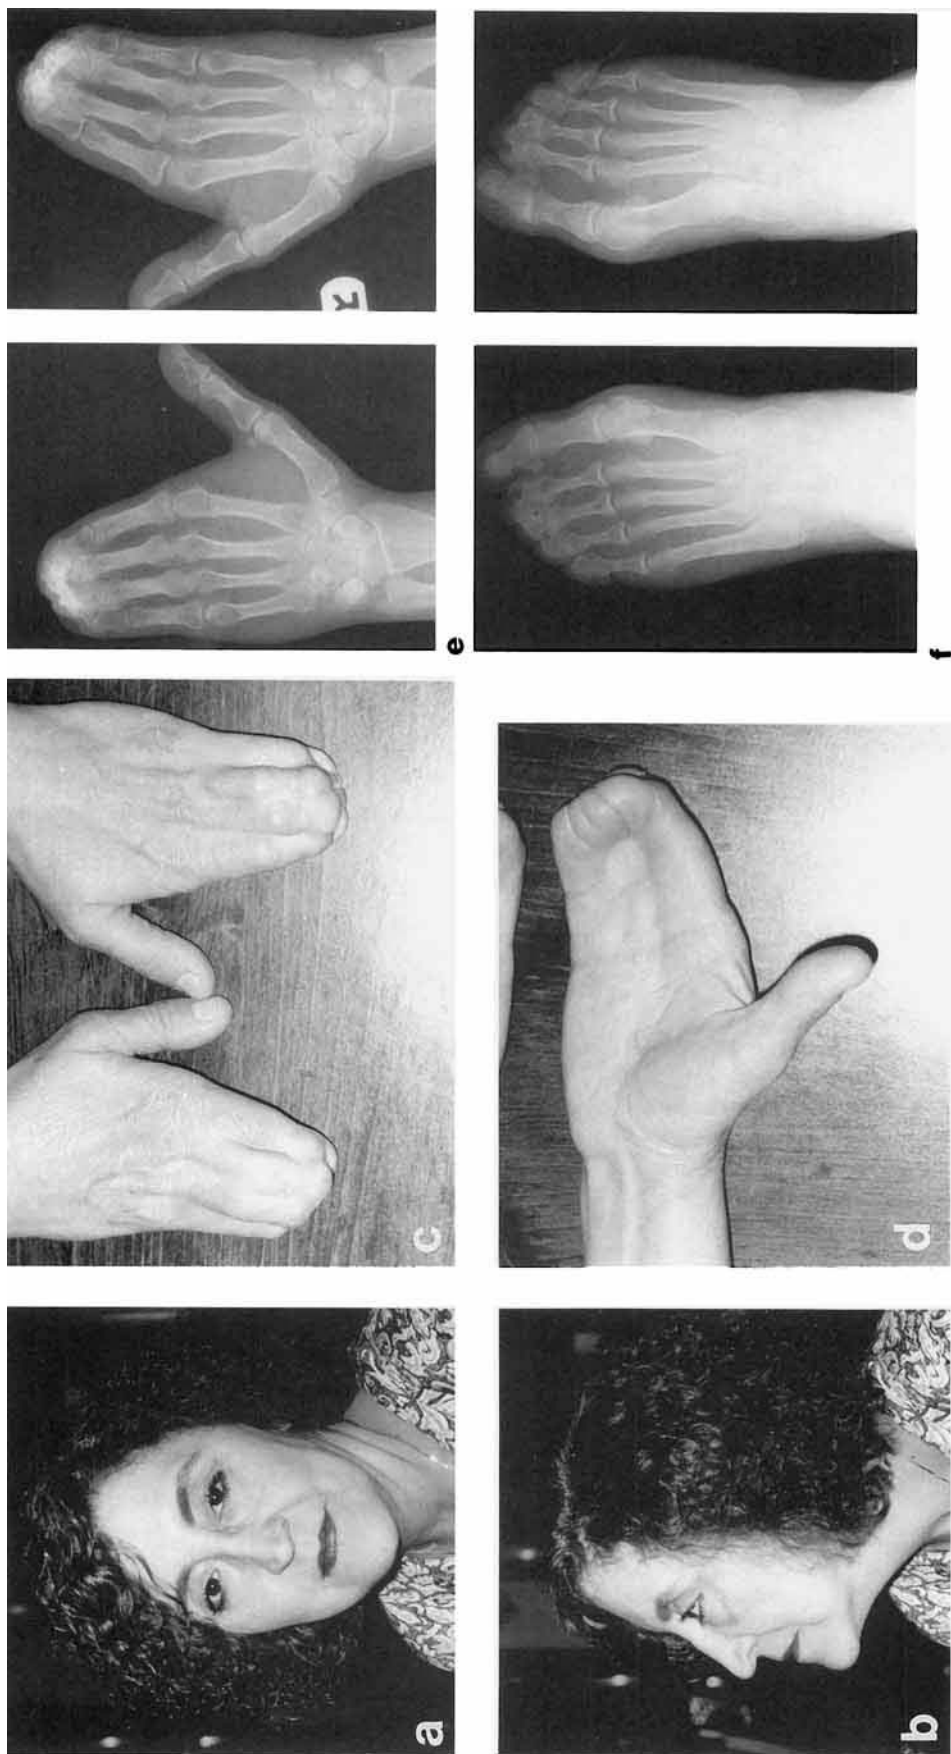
Individual III-4: frontal view (a), profile (b), dorsal (c), and ventral view (d) of unrepaired hands; radiographs of hands (e), showing bony fusion of terminal digits 2-5, and the feet (f), showing fusion of terminal digits 2 and 3.
